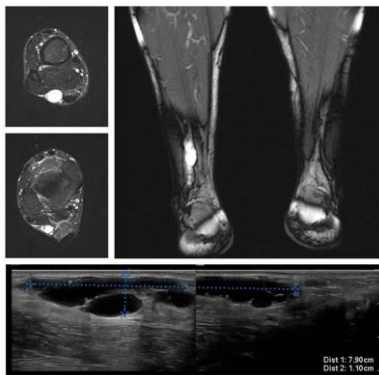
T2 weighted MRIs (upper panel) and ultrasonography (lower panel) of the sural intraneural ganglion.
